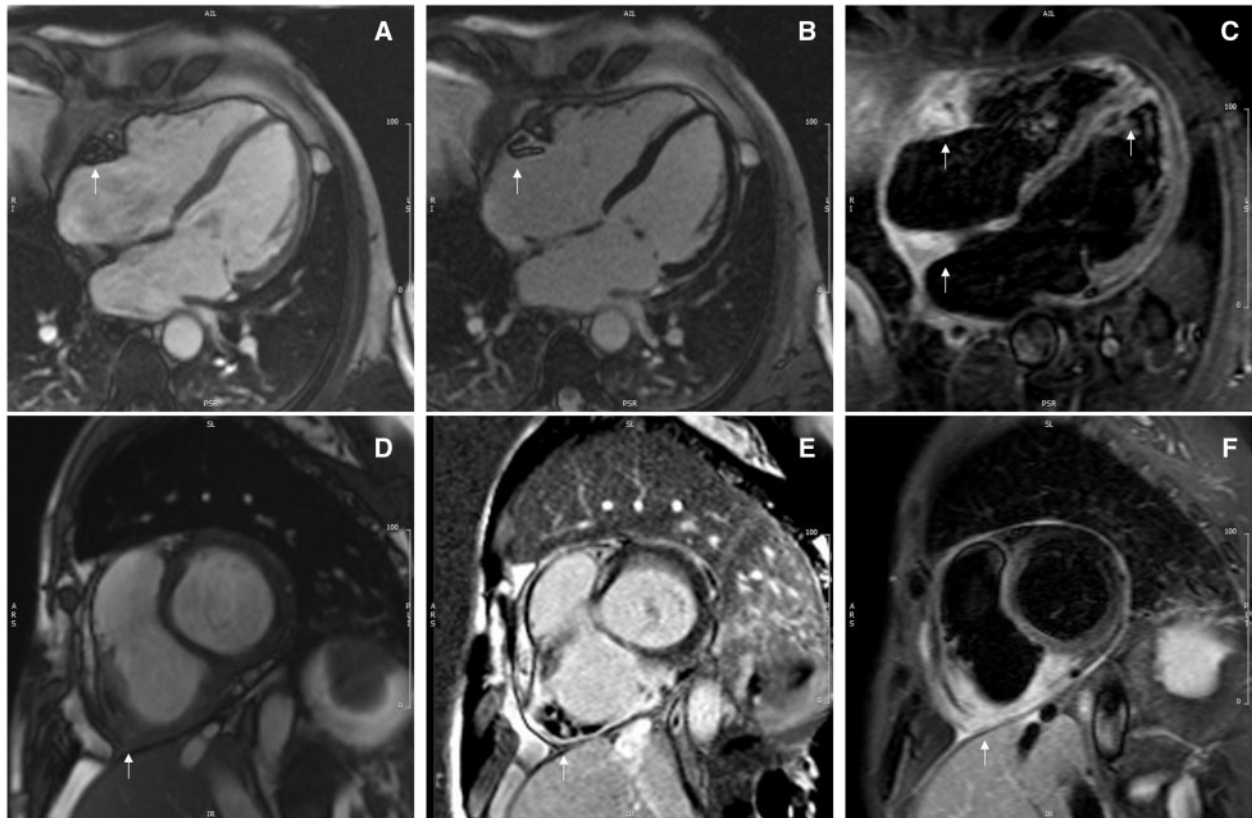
First cardiac MRI scan. (A) Four-chamber early gadolinium enhancement (EGE) showing RA thrombus (arrow, images A–E), (B) four-chamber late gadolinium enhancement, (C) four-chamber STIR with marker showing myocardial oedema of RA septum and infero-lateral wall (arrows), (D) short-axis (SAX) CINE showing RA thickening (arrow), (E) SAX late gadolinium enhancement and phase sensitive inversion recovery (PSIR) showing extensive enhancement of RA with mural thrombus (arrow), and (F) SAX STIR imaging showing extensive myocardial oedema of inferior wall (arrow).
